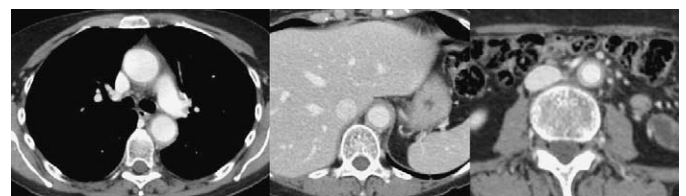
Contrast-enhanced computed tomography of the chest and abdomen: regular thickening of the thoracic and abdominal aortic wall indicating aortitis in a 64-year-old woman with giant cell arteritis.
